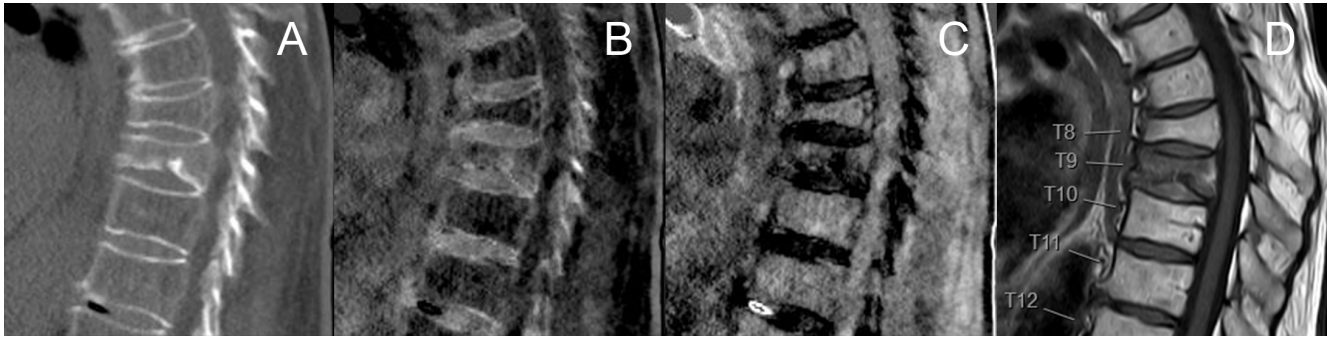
Images of a patient's spine with acute fracture in thoracic vertebra T9. Fig. 3A shows the fracture in conventional CT. Fig. 3B and 3C show the corresponding water- and fat-based images. Fig. 3D shows the magnetic resonance image (MR). In the case of acute vertebral fractures, fat-dominated marrow is replaced by the water-dominated marrow, which is not visible in conventional CT; these patients are likely subject to additional MR scans.
